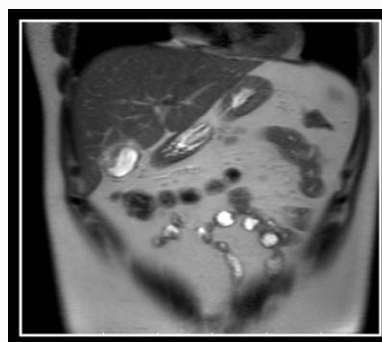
MRI can show hyperintense signal on T2-weighted images of the gallbladder ampicrine carcinoma.
